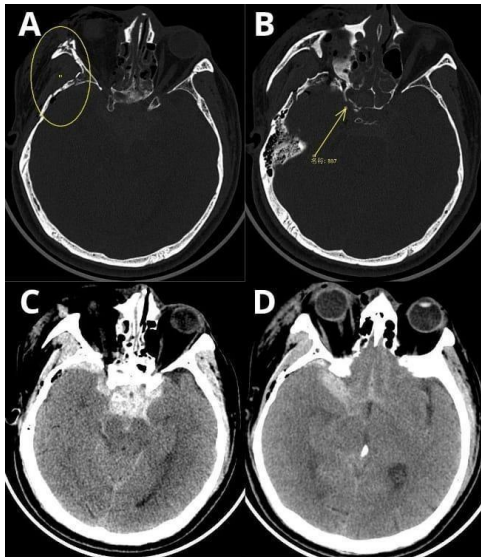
Initial non-contrast head CT following trauma. (A) Skull base fracture involving the lateral wall of the right cavernous sinus. (B) Bone window image showing a fracture line adjacent to the cavernous ICA. (C) Hyperdensity in the right cavernous sinus region, compatible with post-traumatic hematoma or venous congestion. (D) Traumatic subarachnoid hemorrhage in the basal cisterns.
